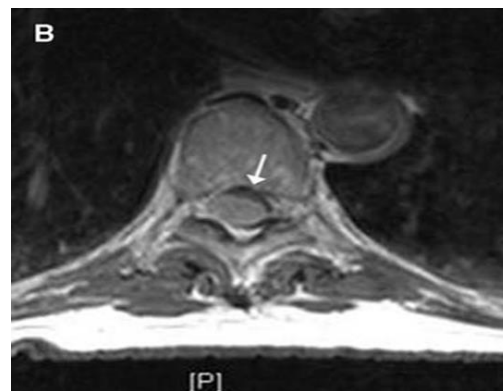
T1-weighted axial contrast MRI scan showing the ventro-lateral displacement of the spinal cord (arrow) due to tumor compression.
